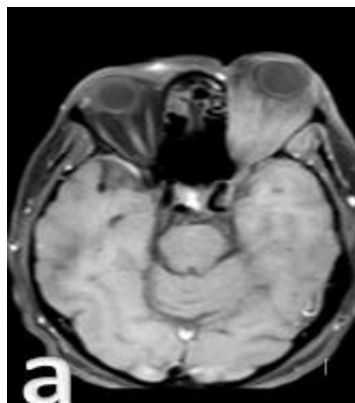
(a&b): post contrast MRI revealed heterogeneous enhancement of the pervious described mass in axial and coronal images respectively.
